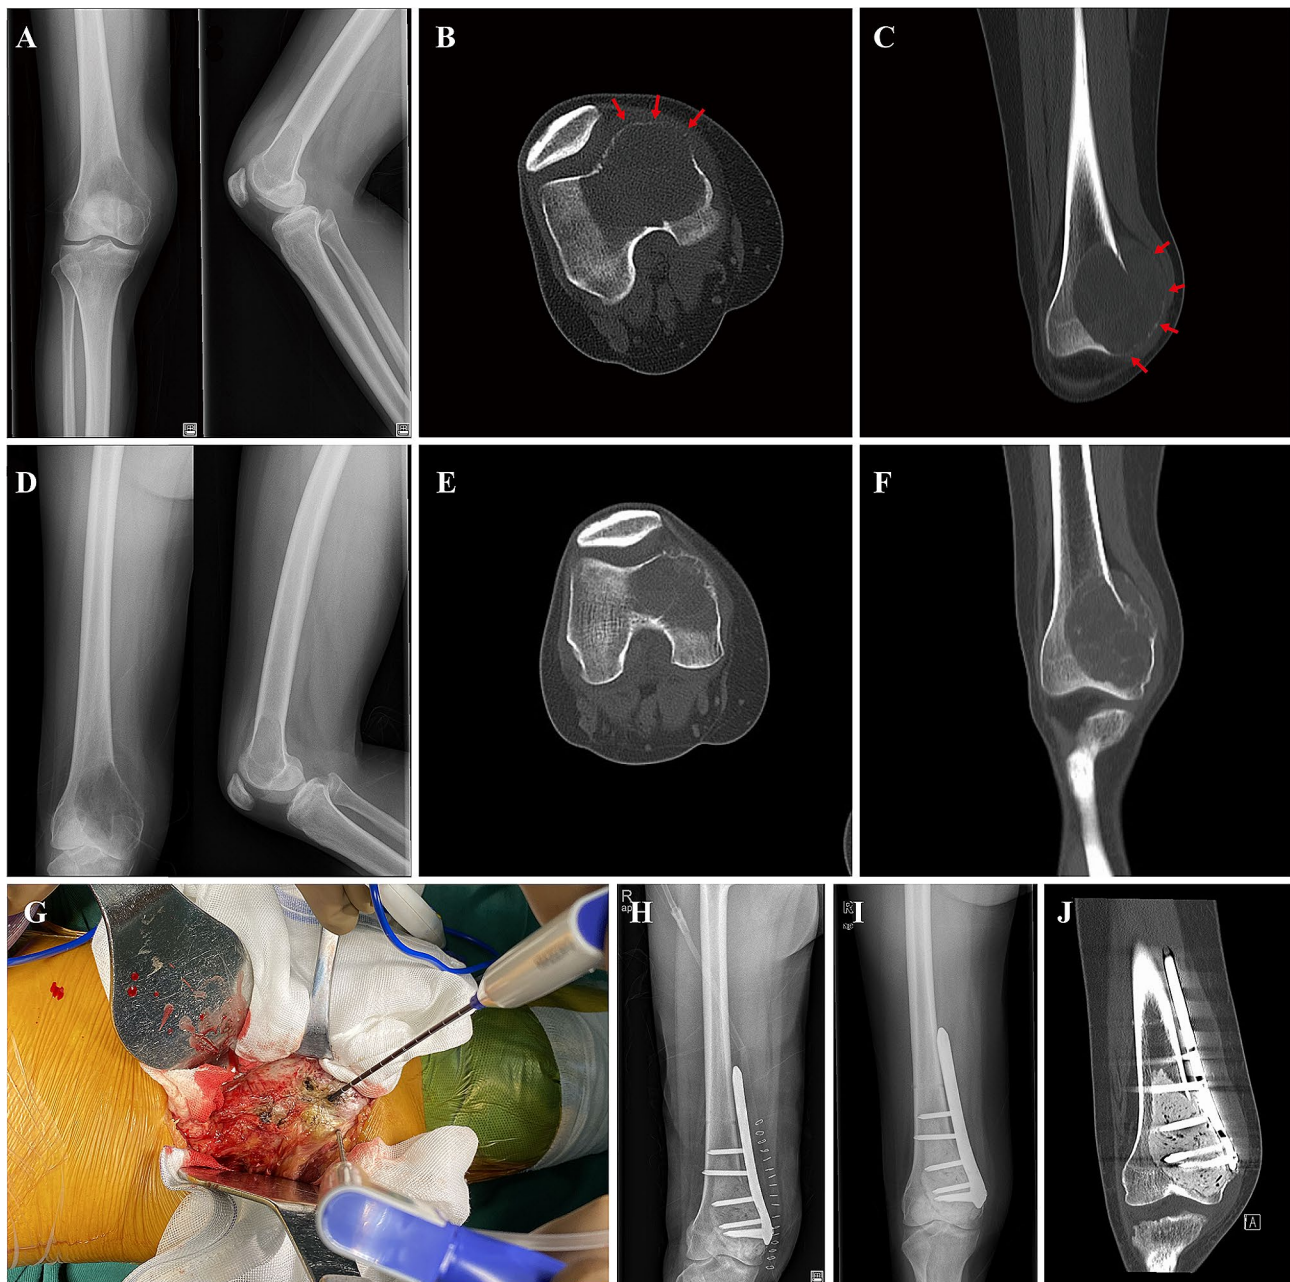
A 33-year-old female patient with a giant cell tumor of the bone in the distal femur preoperatively received three doses of denosumab treatment. Anteroposterior plain radiograph (A) and CT image (B, C) showed an expansile osteolytic lesion with periarticular bone loss and minimal subchondral bone (as indicated by the red arrows). Anteroposterior plain radiograph (D) and CT image (E, F) six weeks after the third injection of denosumab showed the formation of a thickened sclerotic rim around the tumor and the margin became clear. The adjacent normal tissues were exposed and protected with gauze, then the microwave ablation was performed (G). The extensive curettage combined with internal fixation was performed following the microwave ablation procedure (H). Follow-up radiograph at 31 months after curettage and no local recurrence was observed (I, J)
